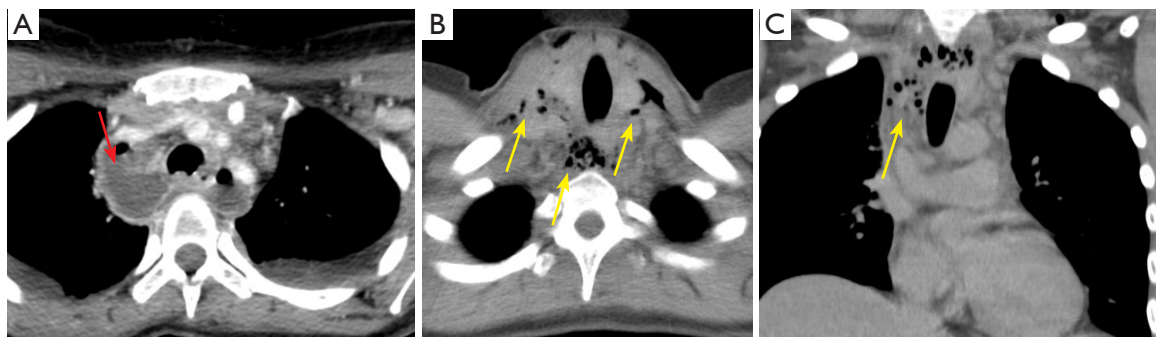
A 60-year-old man with odontogenic infection who developed neck and mediastinal infection as seen by foci of gas. (A) Axial view chest CT scan showing upper mediastinal involvement and rim-enhancing fluid collections (red arrow). (B) Axial view chest CT scan showing multiple foci of gas because of infection in the neck (yellow arrows). (C) Coronal view chest CT scan showing gas in the mediastinum (yellow arrow). CT, computed tomography.
